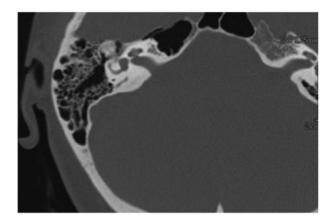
Axial computed tomography scan showing the right-sided malleo-incudal osteoma.
